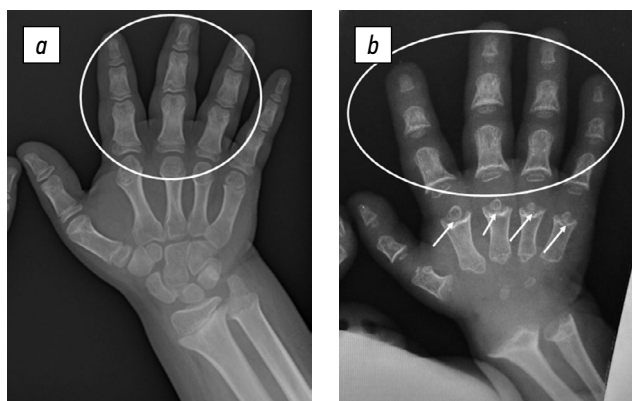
Radiographs of the hands of a patient with achondroplasia (a) and pseudoachondroplasia (b): moderate ulnar deviation of the hand and brachydactyly in both patients (marked with a white outline), and shortening of the metacarpal bones with scaphoid expanded metaphyses, and small rounded ball-in-socket epiphyses in patients with pseudoachondroplasia (white arrows)
